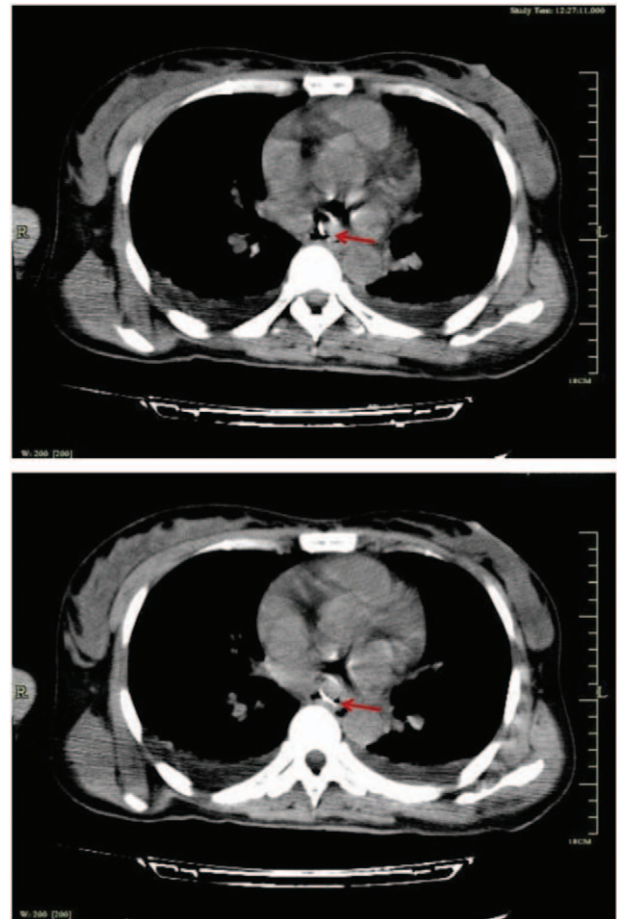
CT scans showing a spiny foreign body perforating through the anterior wall of the esophagus and into the left atrium (arrow). CT = computed tomography.
